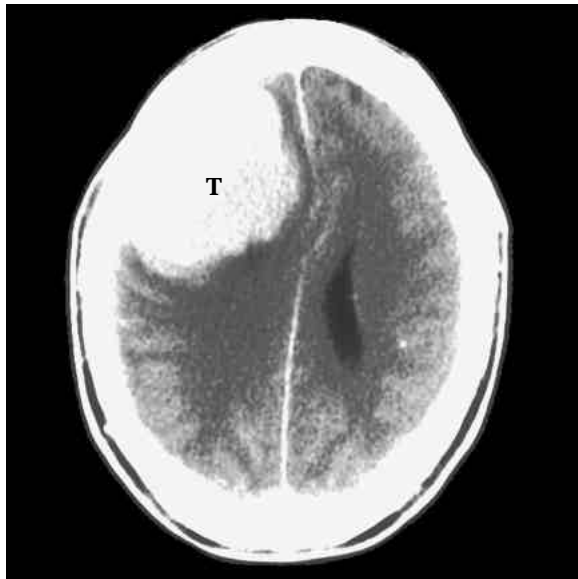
MENINGIOMA T1 MRI. The meninges are three membranes surrounding the brain and spinal cord. From superficial to deep, the meninges are the dura mater, arachnoid, and pia mater. A meningioma is a benign, encapsulated tumor (T) that arises from the arachnoid. This meningioma is compressing the surrounding nervous tissue.
